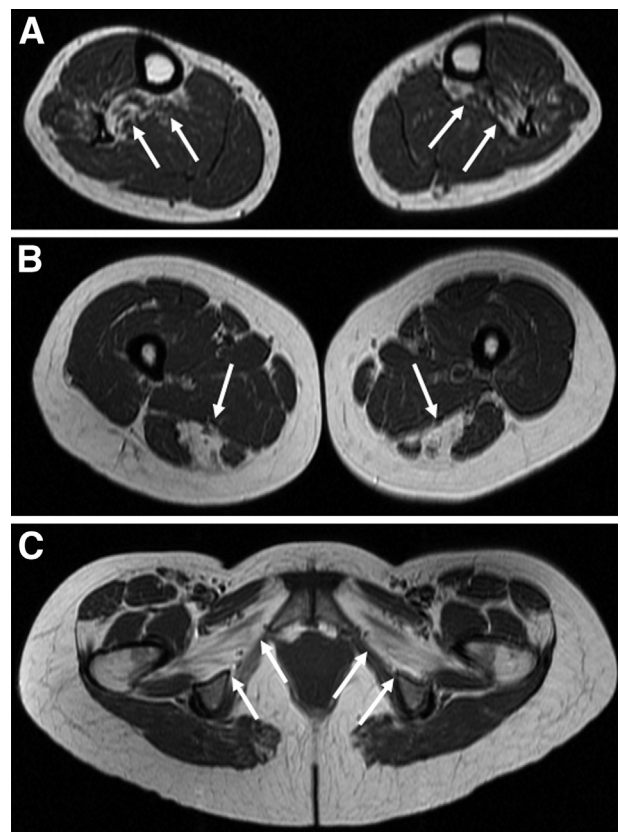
A: Muscle magnetic resonance imaging in a 48-year-old female hereditary myopathy with early respiratory failure patient with a dominant heterozygous p.C30071R mutation in A-band *TTN* gene shows selective dystrophic changes in the lower legs and early fatty degenerative replacement in the tibialis posterior and flexor digitorum longus muscles (arrows). B and C: In the thigh (B), highly selective replacement is observed in the semitendinosus muscles, and in the pelvis (C), it is seen in the obturatorius muscles (arrows).
